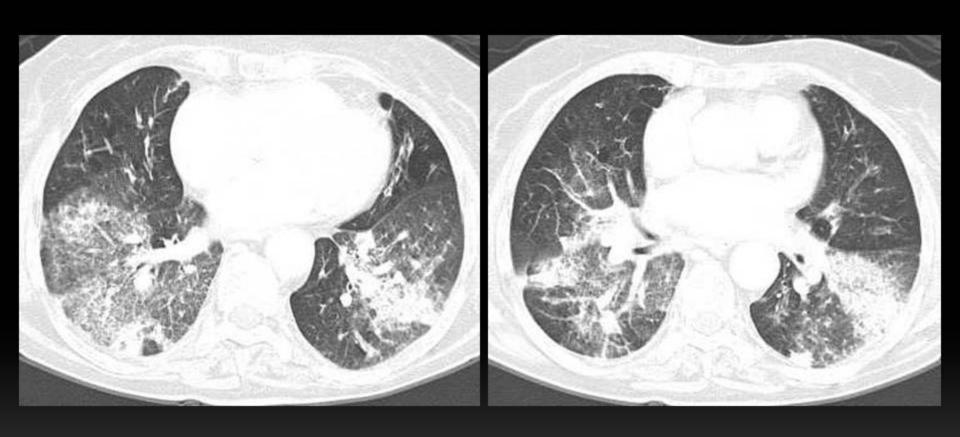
Woman, 78 years old with history of Wegener's granulomatosis and hemoptysis. Thoracic CT shows bilateral patchy ground-glass opacities, thickening of interlobular septa and a consolidation with air bronchogam in the left lower lobe, suggesting of diffuse alveolar hemorrhage.
